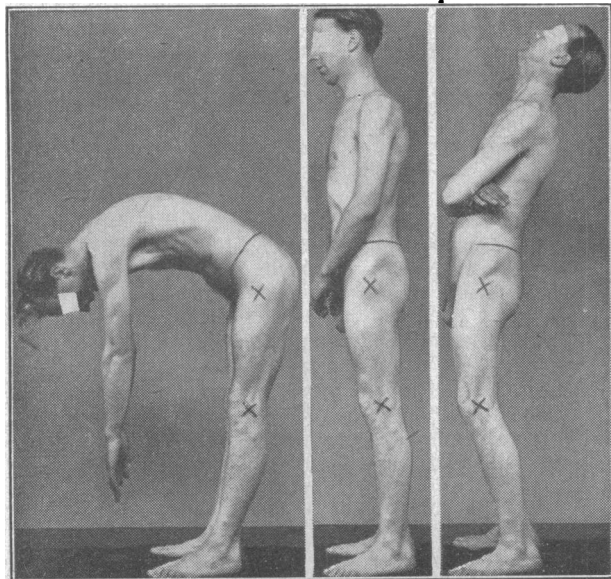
Two months after x-ray treatment
